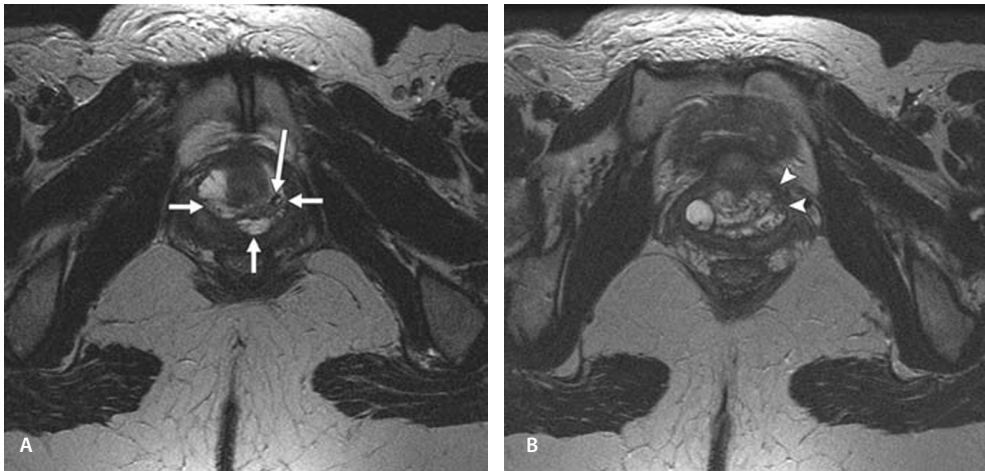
39-year-old-woman with urethral diverticulum imaged with pelvic phased-array coil. A, Axial T2-weighted image shows circumferential urethral diverticulum (short arrows) with internal inhomogeneity as a result of debris, septa, and stone (long arrow). B, Axial T2-weighted image shows unsharp margins of diverticulum, best seen on left (arrowheads), which is caused by perilesional inflammation (pathology proven). Ostium of this complicated urethral diverticulum was considered by two observers as “not identified” and “uncertain,” respectively.
